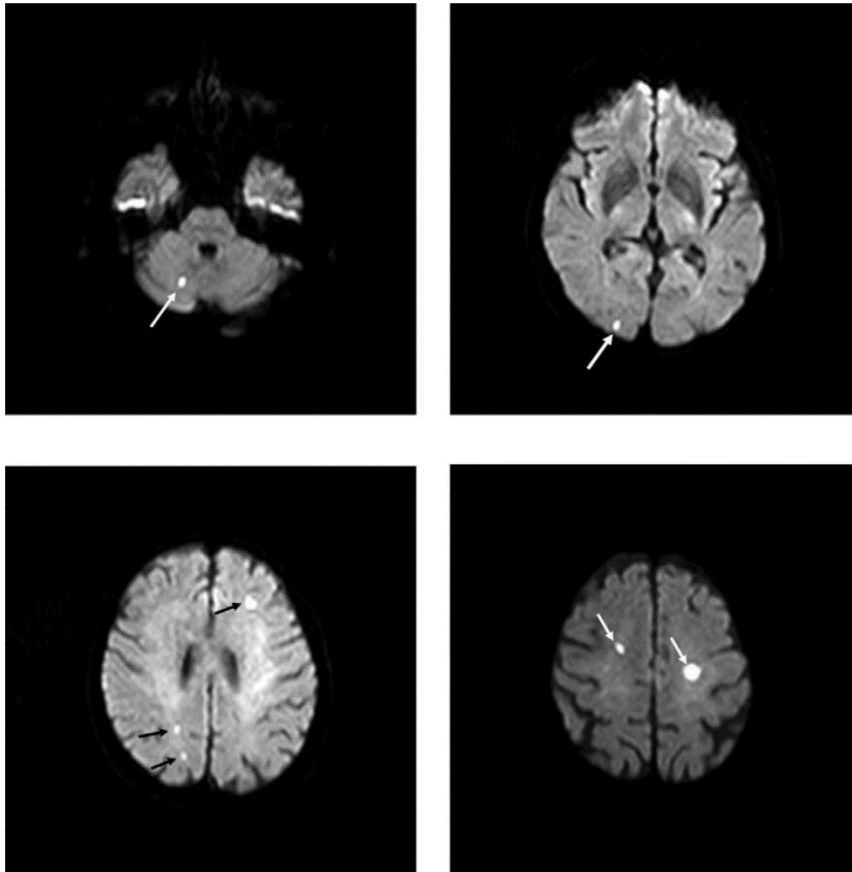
DW-MRI images of TAVI patient brains demonstrating cerebral lesions (Rodés-Cabau et al. 2011).
